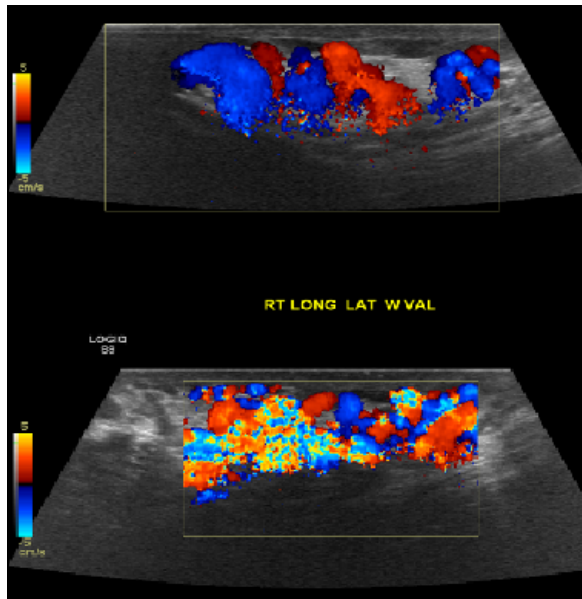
Doppler ultrasound shows dilated serpiginous veins within the testicles bilaterally, consistent with varicoceles.
